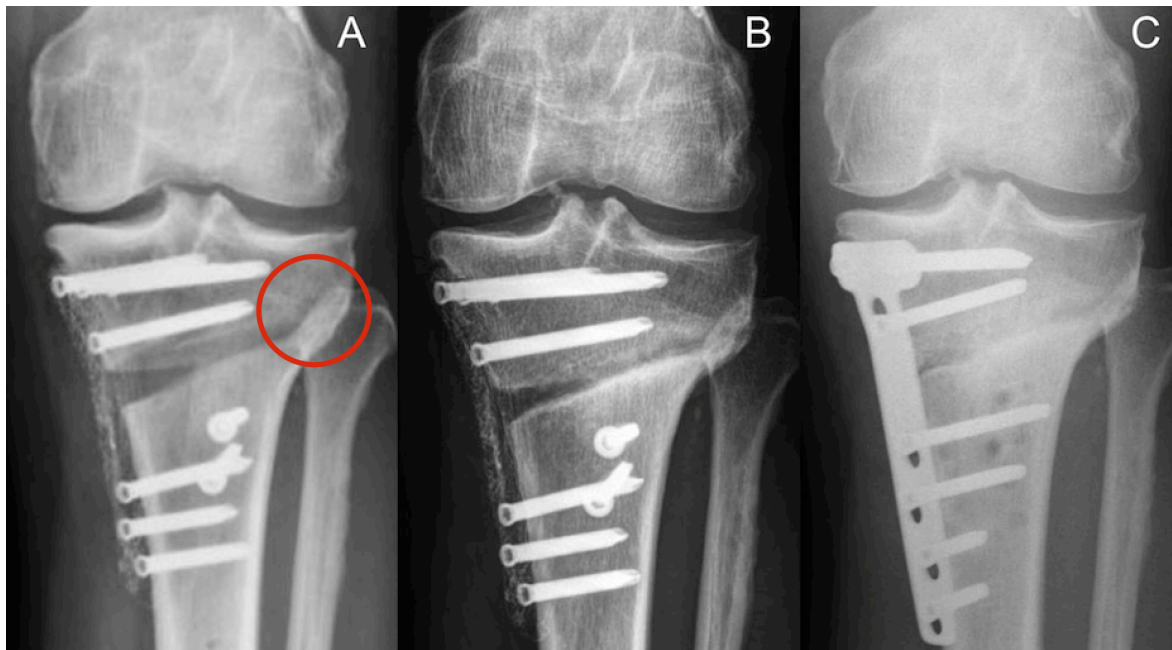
Postoperative AP radiograph at the inpatient stay might show a minimal fracture of the lateral cortex (red circle) in a 57 year old male smoker (BMI: 28 (kg/ m²)) (A). After a diagnosed non-union with persistent pain (B), this patient was successfully treated by filling of the osteotomy gap with autologous cancellous bone from the iliac crest at nine months after ow HTO. The surgeon decided to replace the PEEKPower HTO-Plate® by the TomoFix™ plate. Thereby it was possible to obtain compression on the lateral hinge by using a temporary lag screw (C). In this patient, removal of the TomoFix™ plate within complete consolidation of the osteotomy gap was done 27 months after initial ow HTO.
